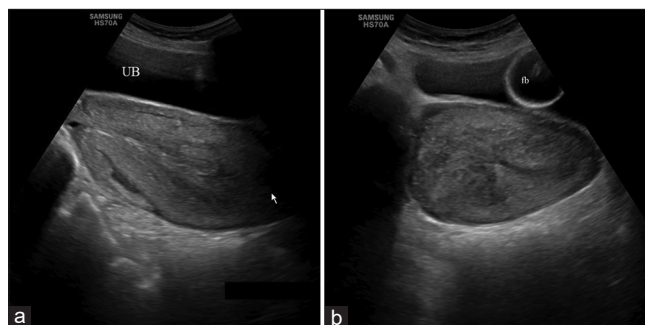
Transabdominal ultrasound image in longitudinal (a) and transverse (b) planes with full urinary bladder (UB) and Foley's bulb (Fb) *in situ*. The arrow points to abnormality
